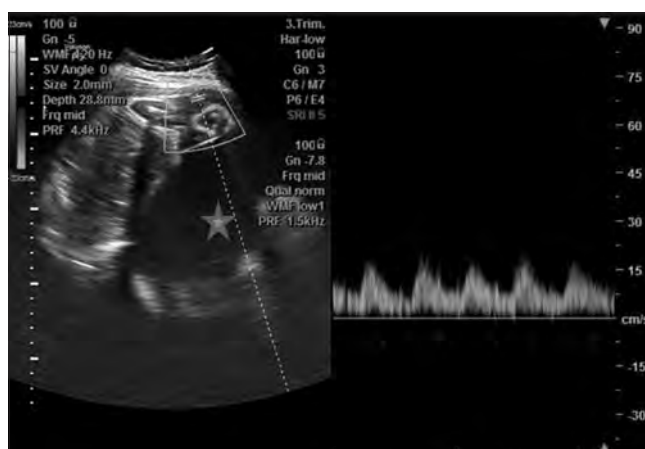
Doppler ultrasound of the umbilical artery of second “stuck” donor twin showing normal spectral wave pattern. Increased fluid (star) is noticed in the sac containing the recipient
